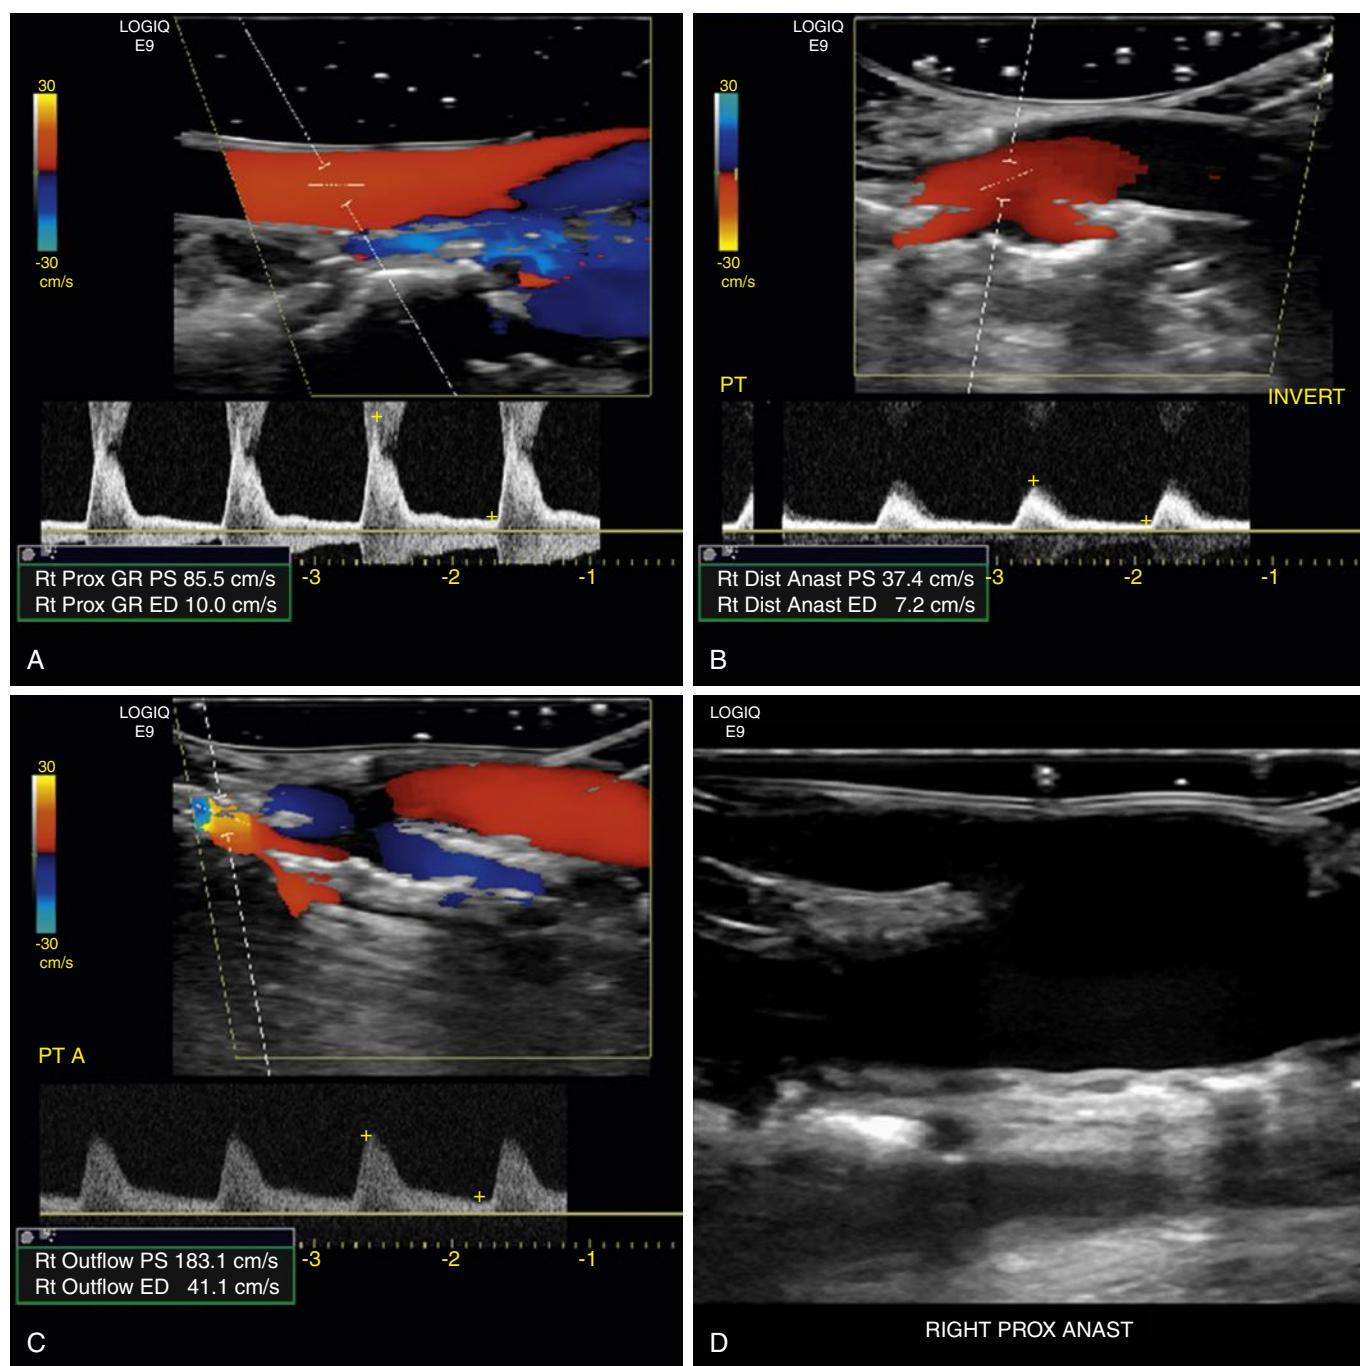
Intraoperative completion duplex ultrasound after a femoral to below-knee popliteal artery bypass graft with vein conduit. (A) The proximal part of the graft shows good diastolic flow as indicated by an end-diastolic (ED) velocity of 10 cm/s. (B) Patent distal anastomosis without stenosis as indicated by peak systolic (PS) velocity of 37.4 cm/s. (C) Antegrade blood flow in the native outflow artery with good diastolic flow as indicated by ED velocity of 41.4 cm/s. (D) No dissection flap, stenosis, or technical complication at the proximal anastomosis as seen on B-mode ultrasound.
